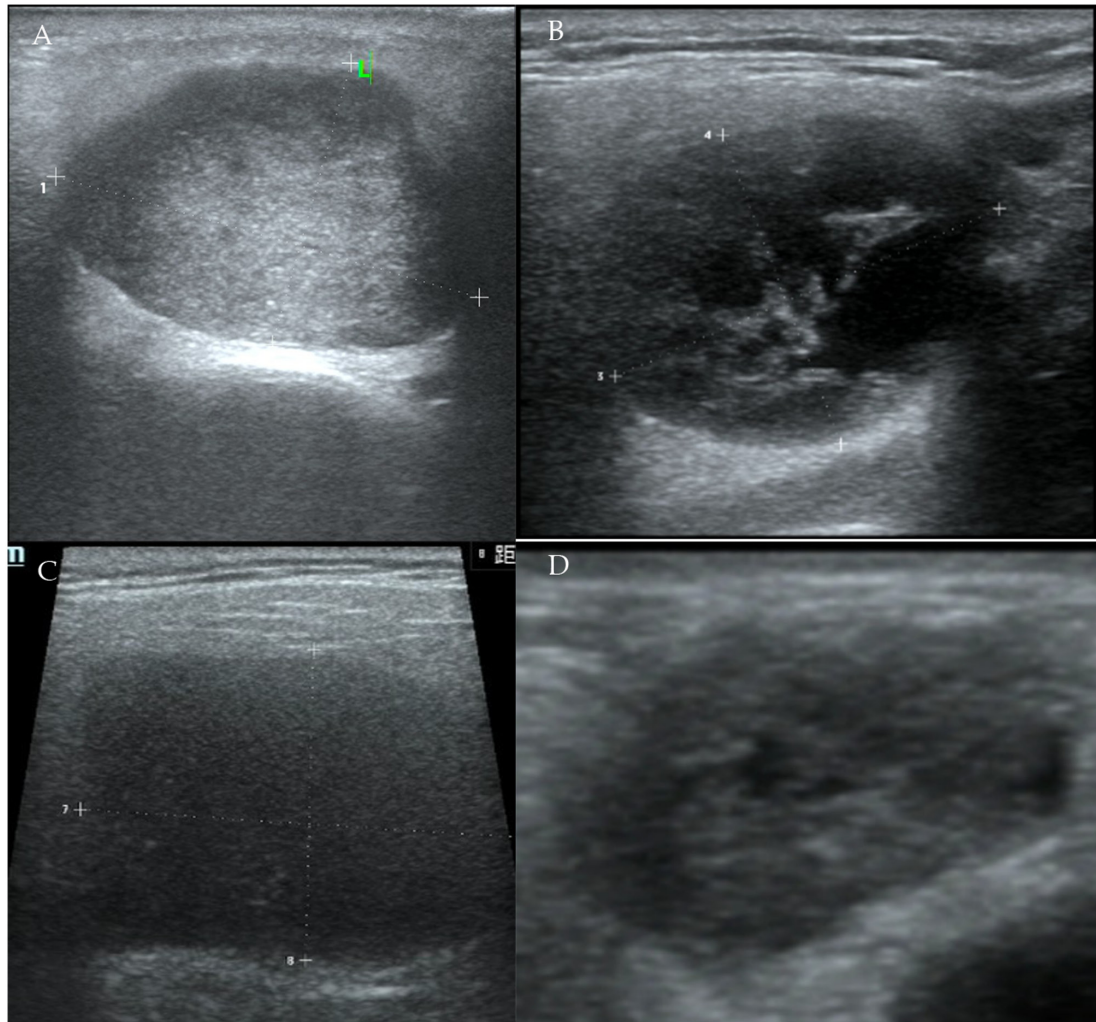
Echogenicity and heterogeneity of parotid gland tumors under ultrasound. (A) Slightly hypoechoic and slightly heterogenic pleomorphic adenoma. (B) Highly hypoechoic and highly heterogenic WT. (C) Highly hypoechoic and slightly heterogenic WT (D) Slightly hypoechoic and highly heterogenic mucoepidermoid carcinoma. WT, Warthin's tumor.
